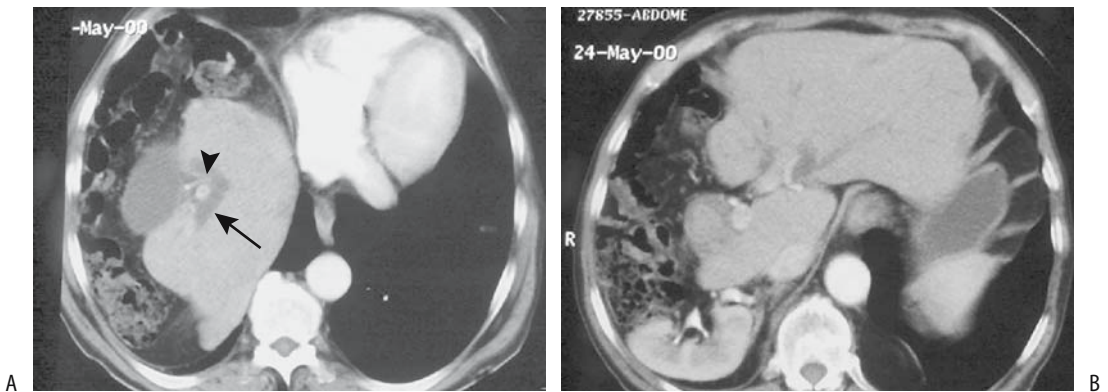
Right lobe atrophy. Two views from contrast-enhanced CT reveal (A) posteriorly located gallbladder, a dilated right hepatic duct (arrow), and an atrophied right portal vein (arrowhead), and (B) left lobe hypertrophy. (Source: Gallego C, Velasco M, Marcuello P, Tejedor D, De Campo L, Frieria A. Congenital and acquired anomalies of the portal venous system. *RadioGraphics* 2002;22:141–159, with permission from the Radiological Society of North America.)
